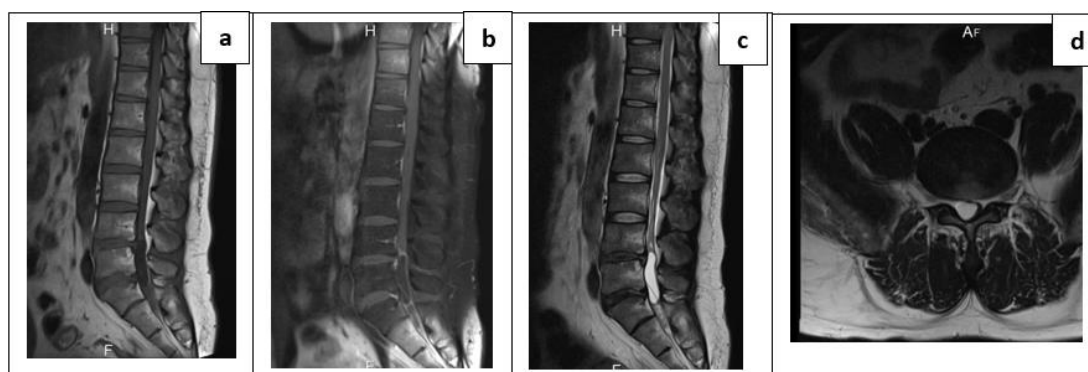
Patient's lumbar MRI.
